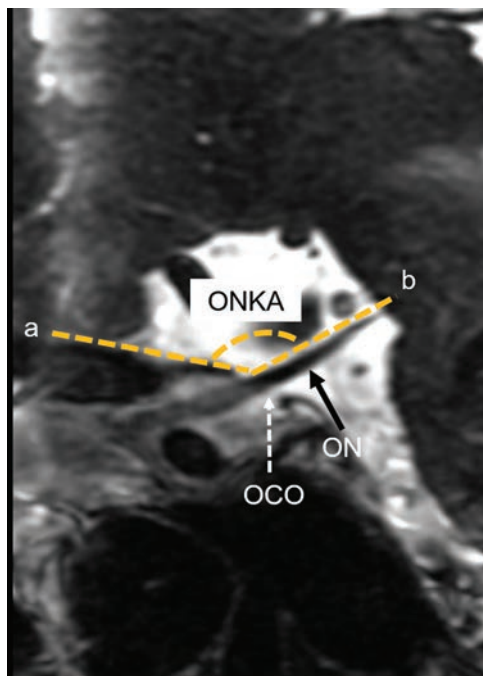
A sagittal oblique CE-FIESTA from a subject with normal brain MR imaging findings shows the optic nerve kinking angle. a = line extending across the anterior cranial fossa, b = line through the intracranial optic nerve. OCO indicates optic canal orifice.
